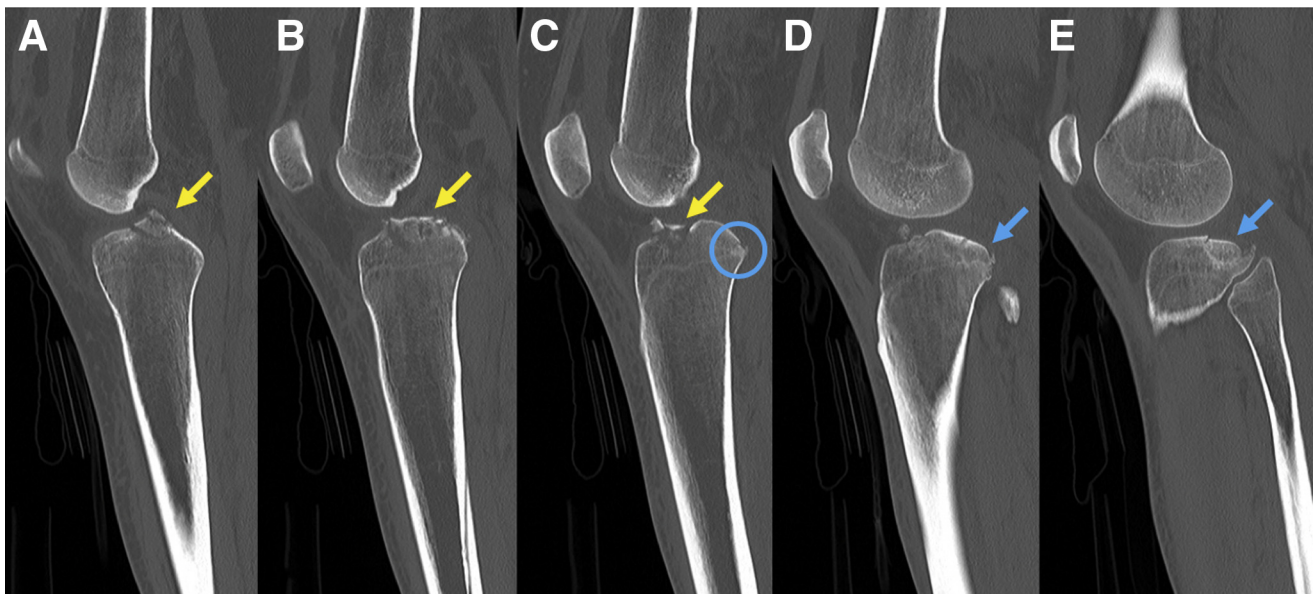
Preoperative computed tomography scan images of a right knee, sagittal view. A complete avulsion fracture of the tibial spine (yellow arrows) is visualized on (A-C). On (C), a fracture of the posterolateral tibial plateau is marked by the blue circle. Extension of the fracture of the posterolateral tibial plateau and its depressed slope (blue arrows) can be seen on (D-E).
